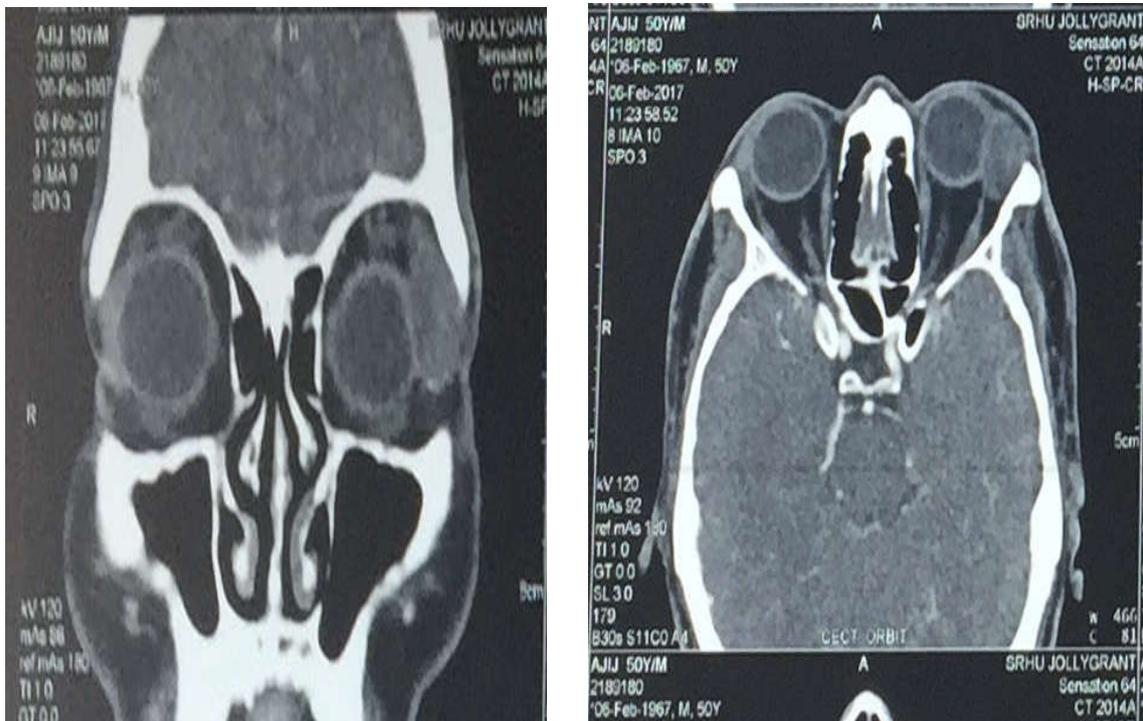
(a). CT Coronal section showing mass (b) CT Axial section showing mass indenting globe
